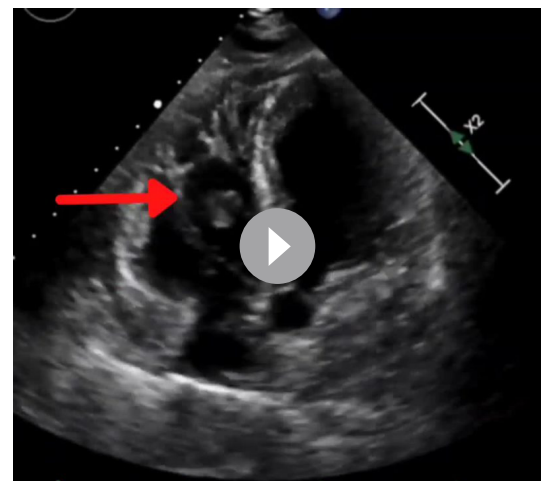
(A) Two-dimensional transthoracic echocardiography shows four-chamber view with right ventricular (RV) type C mobile thrombus (marked in red arrow). (B) Three-dimensional transthoracic echocardiography of the RV thrombus (marked in red arrow). LV, Left Ventricle; LA, Left Atrium; RA, Right Atrium.
